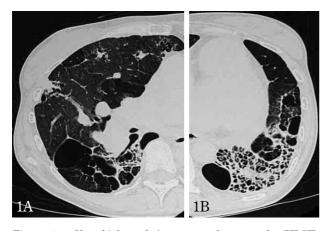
Chest high resolution computed tomography (HRCT) shows multiple cystic lesions and interstitial fibrotic changes in the bilateral lung fields. Honey-comb like appearance is observed in the left and back side.
